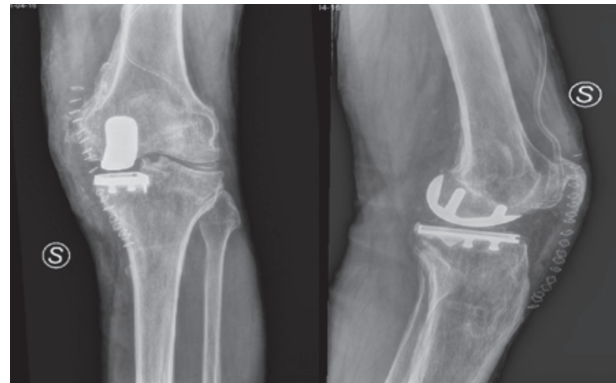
Postoperative radiographs of the left knee following UKA implantation
